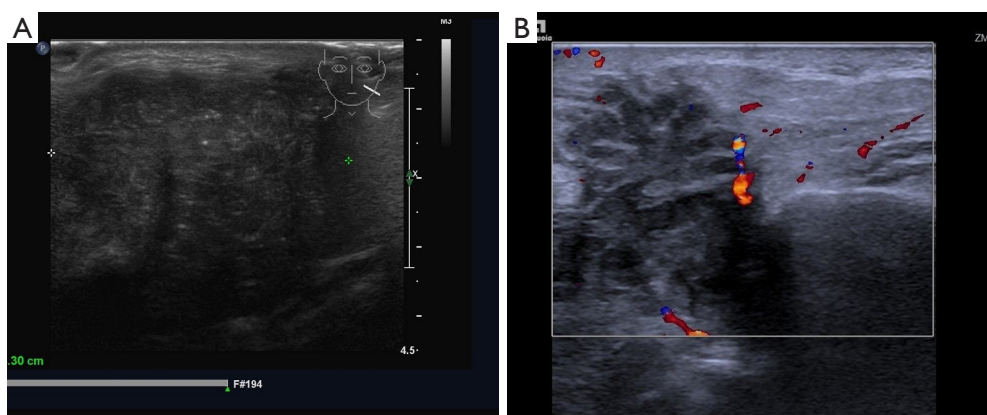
Malignancy risk grade 3. (A) A round hypoechoic nodule in the parotid gland with clear margin and regular shape. CDFI shows abundant blood flow signals within it. The pathological result was basal cell adenoma. (B) A round hypoechoic nodule in the parotid gland with clear margin, regular shape, multiple linear strong echoes in a mesh pattern inside. The pathological result was Warthin's tumor. CDFI, color Doppler flow imaging.
